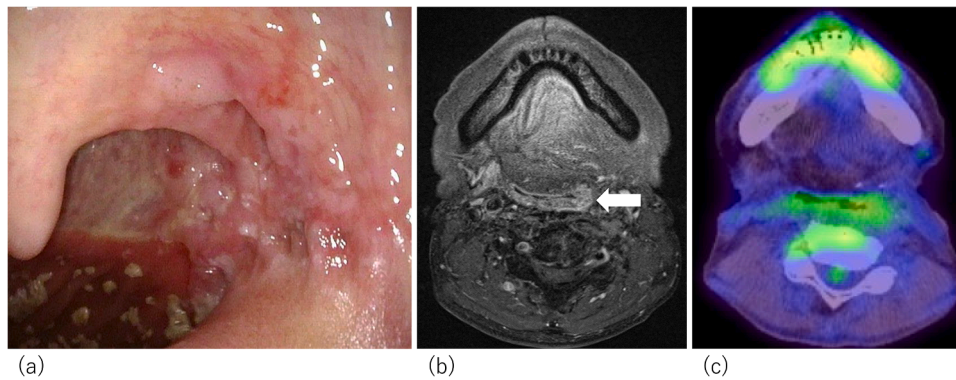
Endoscopic examination revealed a mass on the left lateral wall of the oropharynx (a). Contrast-enhanced cervical MRI demonstrated a lesion at the site indicated by the arrow (b), whereas FDG-PET showed only mild uptake at the corresponding site (c).
